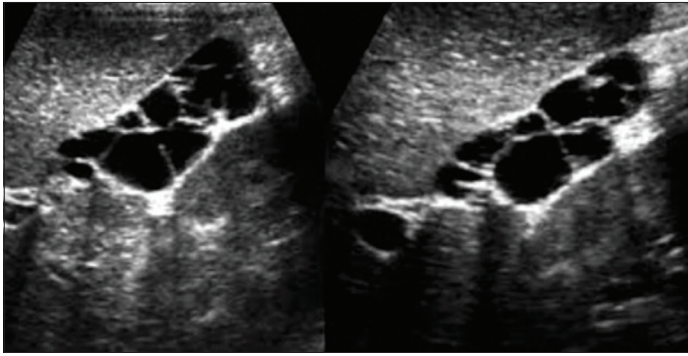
Ultrasound abdomen showing multiple septation
